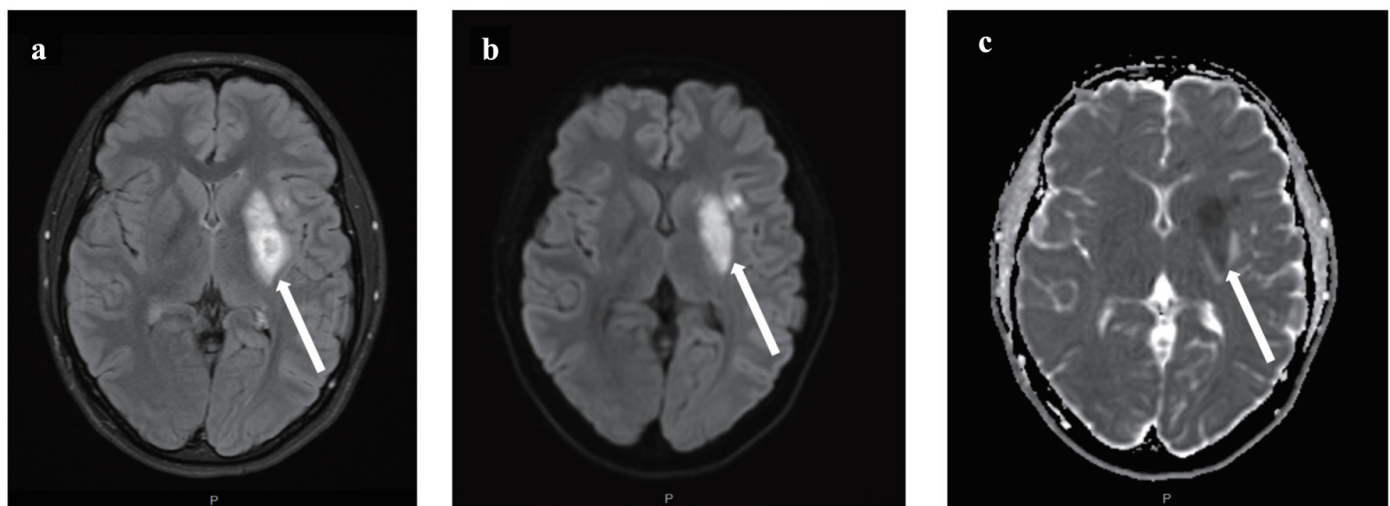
Post-treatment magnetic resonance imaging of the brain demonstrates evolving infarction without hemorrhagic transformation. Arrows indicate regions of infarction involving the left caudate tail, lentiform nucleus, and corona radiata. (a) Fluid-attenuated inversion recovery imaging. (b) Diffusion-weighted imaging. (c) Apparent diffusion coefficient map confirms true diffusion restriction.
